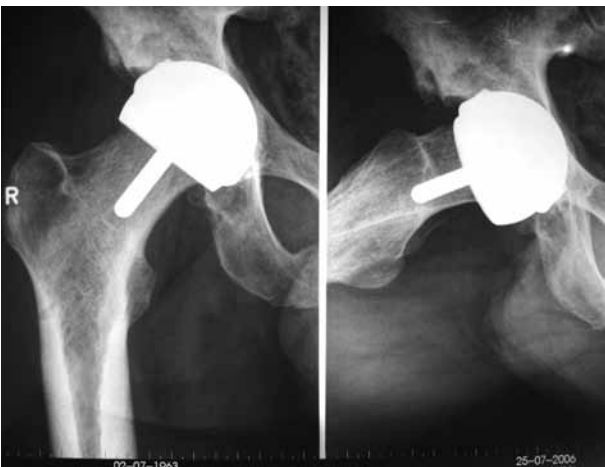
Post-operative radiograph showing the correctly implanted hip resurfacing implants.
